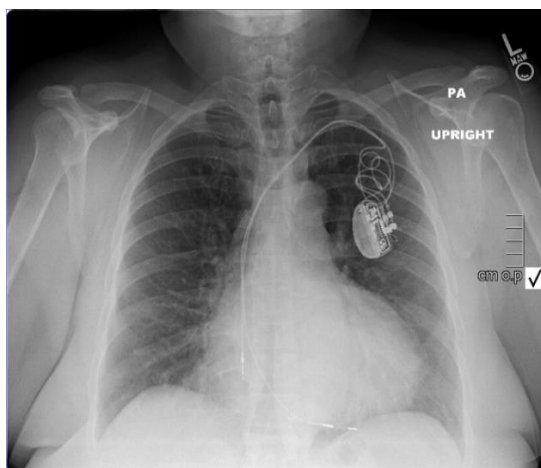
Chest X-ray on presentation. Twisted pacer wires (white arrow) causing malfunction of patient's pacemaker
